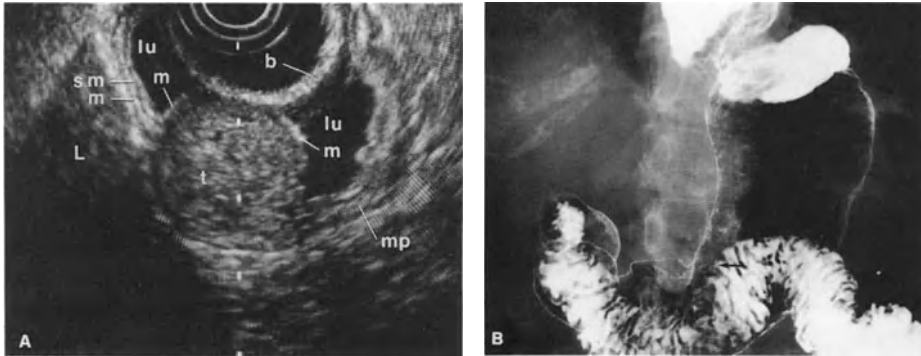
A Endoscopic sonogram showing a round homogeneous hypoechoic echo pattern (*t*) protruding into the lumen (*lu*) covered with normal mucosa (*m*), which is strongly suggestive of leiomyoma. *L*, liver; *sm*, sub-mucosa; *mp*, muscularis propria; *b*, water-filled balloon. B Barium meal radiogram showing a smooth round double contour at the lesser curvature (*arrow*)
